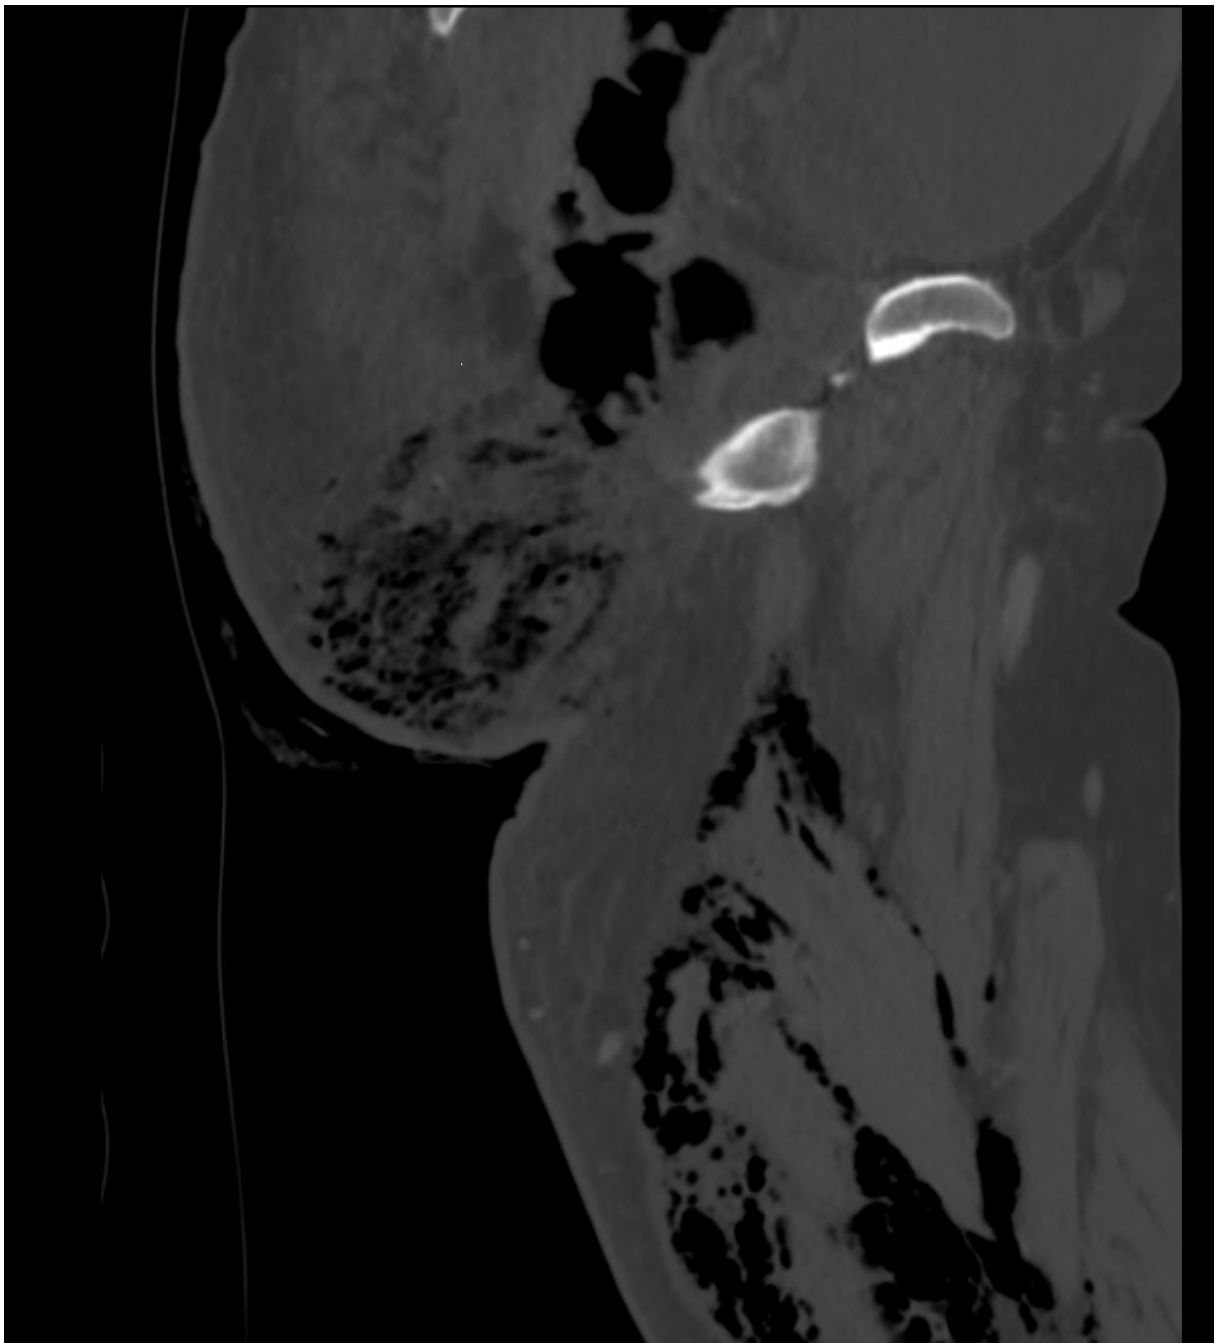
Contrast-enhanced CT of the upper leg, sagittal plane.
